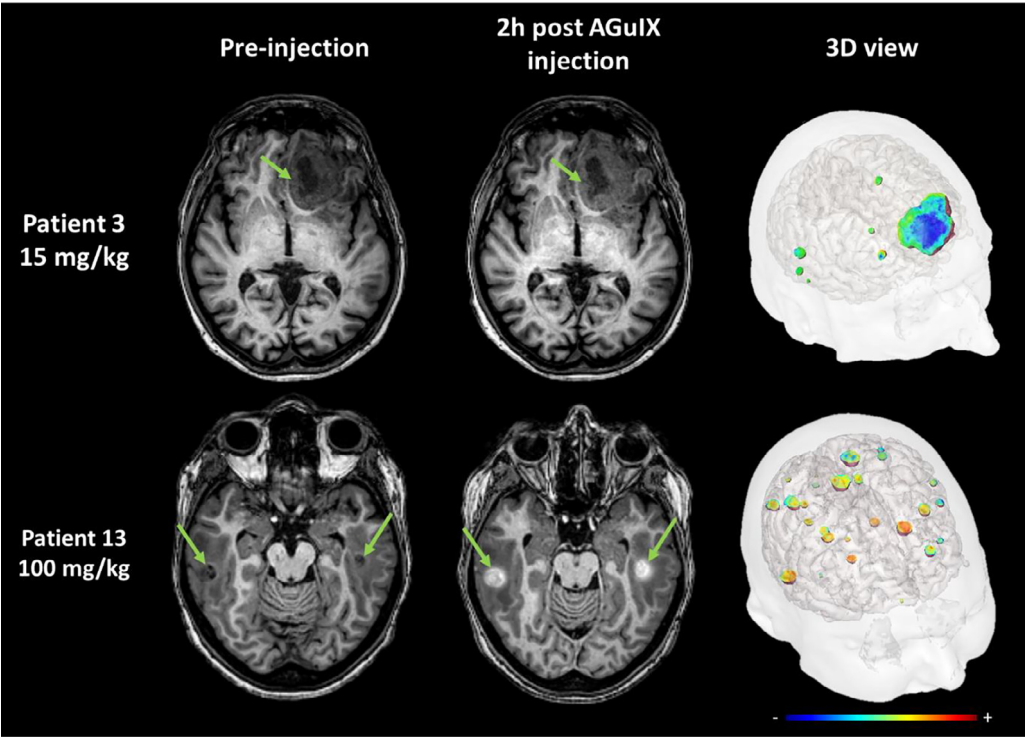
AGuIX contrast-enhanced MRI at 2 h in brain metastases of 2 patients with lung cancer following intravenous AGuIX administration at 15 and 100 mg/kg respectively. AGuIX, Activation and Guidance of Irradiation by X-Ray; MRI, magnetic resonance imaging. T₁-weighted MRI images were obtained without injection of contrast agent before and at 2 h after a single AGuIX intravenous administration at the indicated concentration. Green arrows are pointing highlighted metastases. The 3-D visualization of entire brain with specific contrast enhancement into metastases was obtained from T₁-weighted MRI mapping.
